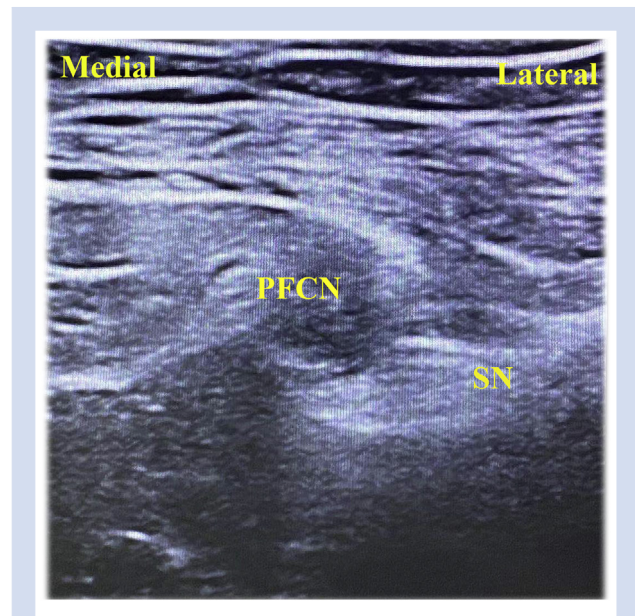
Ultrasound image of PFCN and SN at the subgluteal crease. PFCN, posterior femoral cutaneous nerve; SN, sciatic nerve.
